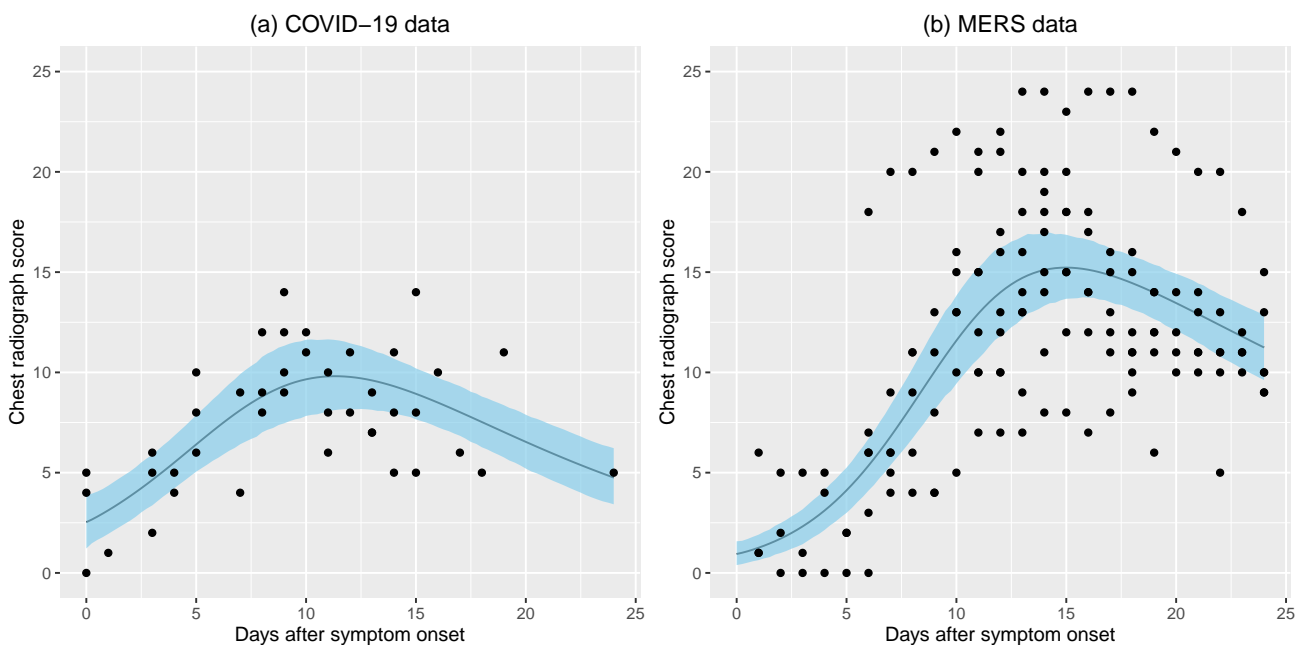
The chest radiograph score data and fitted result of (a) COVID-19, and (b) MERS. The dark line is the mean value of fitted result, while, the 95% Highest Posterior Density interval is shown in blue. The black points are the chest radiograph score data.
